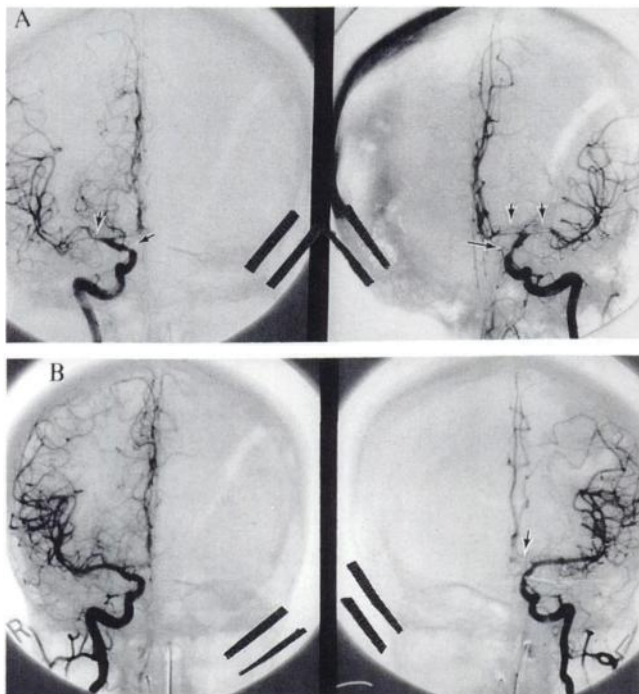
(A) Pre-angioplasty angiogram of Patient 2 (see Table 1) from bilateral internal carotid artery injections (left on right side of photo, right on left). Arrows show right middle cerebral, right supraclinoid carotid, left middle cerebral, left anterior cerebral and left supraclinoid carotid arterial spasm. (B) Post-angioplasty angiogram. Residual stenosis is present in the left ACA (arrow) which was not amenable to balloon dilatation because it could not be reached. Because of the successful dilatation of the other vessels and restoration of good collateral circulation, however, the patient did not sustain an infarct. This patient had no residual regional cerebral blood flow deficit on the post-angioplasty SPECT.
